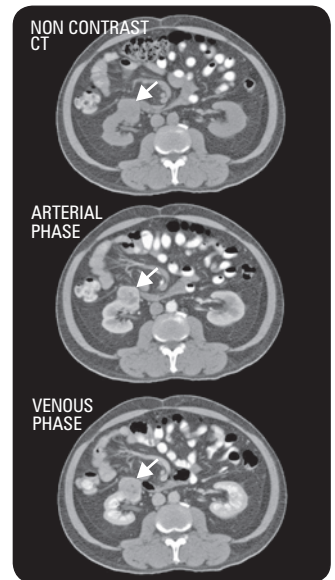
Triphasic CT of a renal cell carcinoma: showing arterial enhancing right renal lesion with venous washout (shunting)
